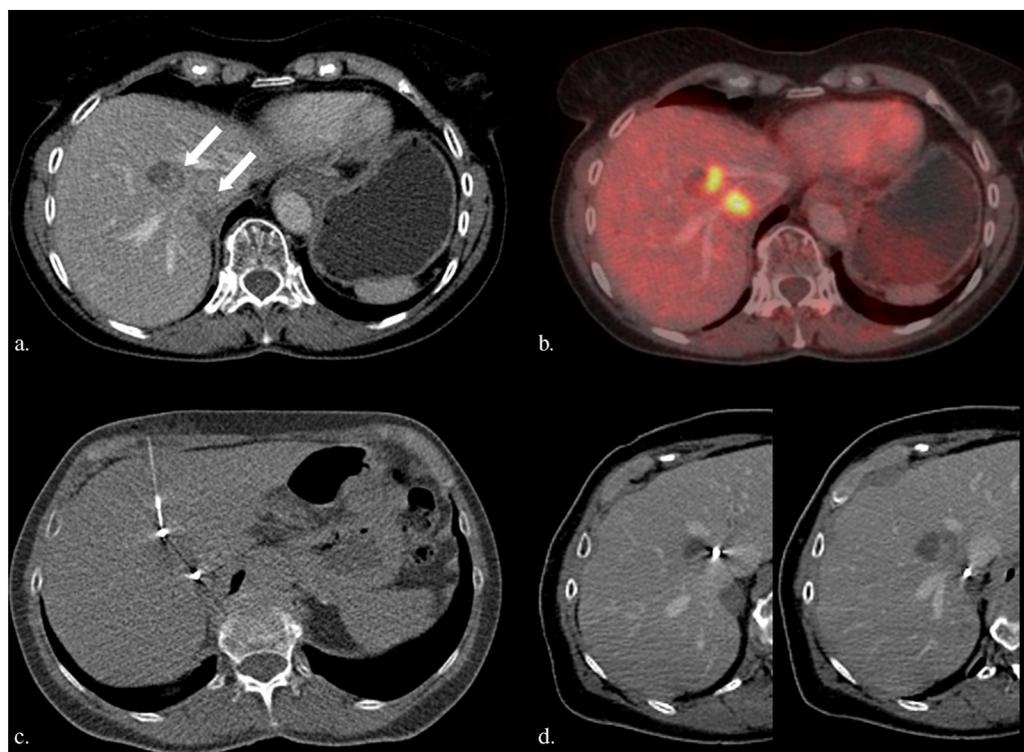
Images from a 69-year-old woman with a history of colorectal cancer 1 year earlier who had undergone radiofrequency ablation of two liver metastases in segments VII and VIII neighboring the vena cava and the large liver veins. Contrast-enhanced portal venous CT scan shows two slightly enhancing local recurrences (arrows) at the margin of the ablation areas (a). On PET/CT, a corresponding hypermetabolism of both metastases is depicted (b). Two fiducial seeds are implanted within the lesions under CT fluoroscopy via an 18-gauge needle (c). The portal venous CT scan performed after the intervention for planning of CyberKnife radiosurgery shows correct intratumoral localization of both fiducial seeds (d). (Available in color online at www.jvir.org.)
